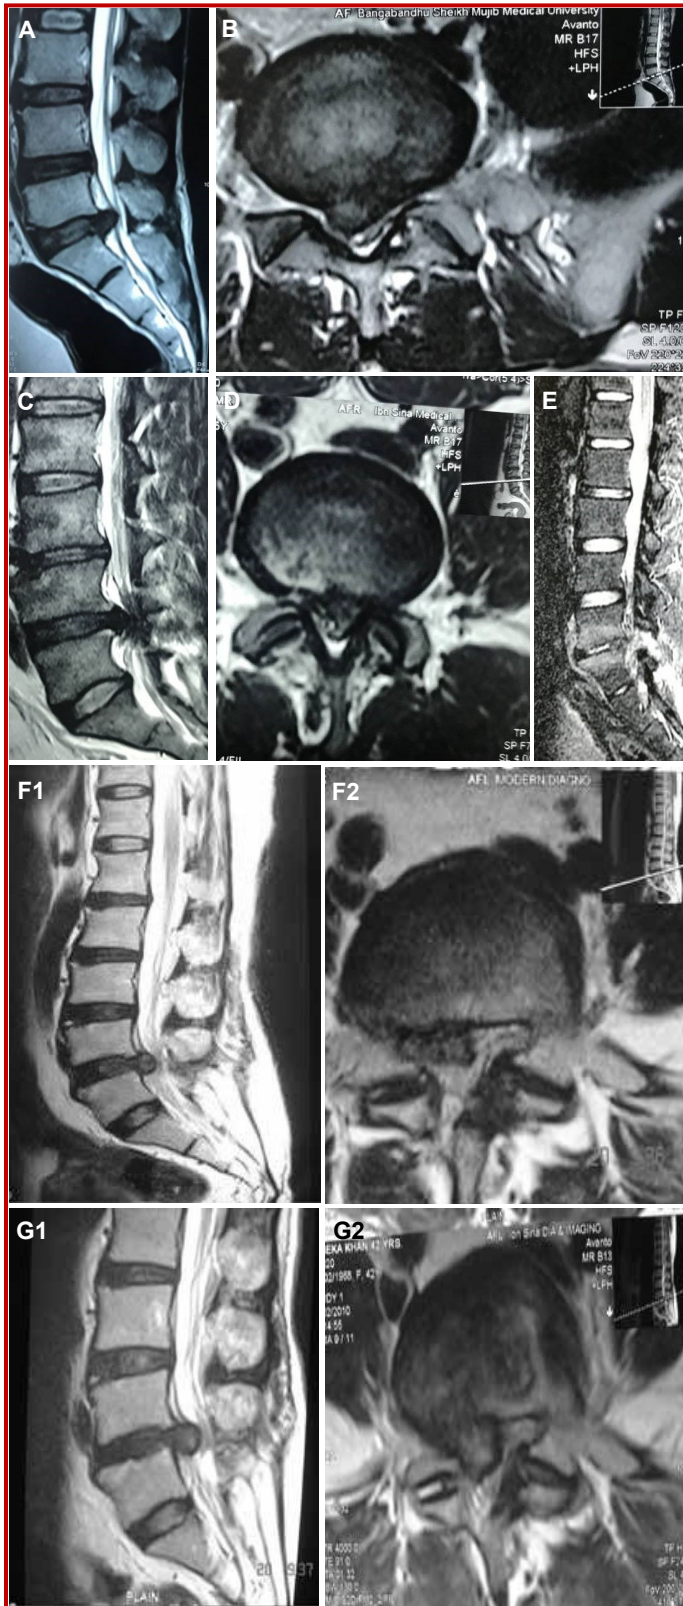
MRI of lumbar disc herniation L5-S1 level (A, B), at L4-5 level (C, D), post-operative discitis (E). Primary (F) and recurrent (G) (1.5 years later) prolapsed lumbar intravertebral disc at L4-5
